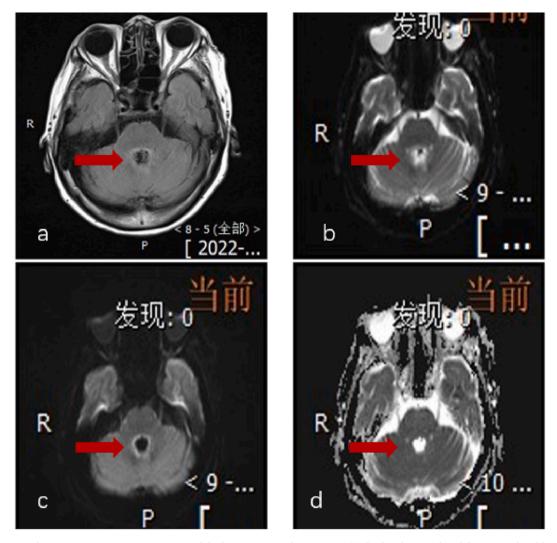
Proton density magnetic resonance imaging of the brain on November 27, 2022.(a)The fourth ventricle exhibits a peripheral hypersignal shadow on T2-FLAIR imaging. (b) there is a slightly increased signal surrounding the fourth ventricle on T2-weighted imaging. (c) On diffusion-weighted imaging (DWI) (b = 1000), there is a slight elevation in signal intensity around the fourth ventricle. (d) The apparent diffusion coefficient (ADC) map demonstrates a slightly decreased signal around the fourth ventricle.
